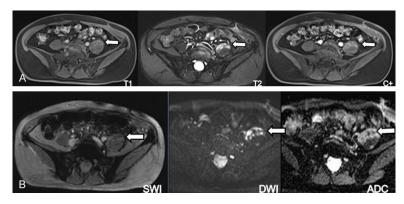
MRI follow-up. A. The mass is iso-and low signal intensity on axial T1-weighted image; hyperintense on T2-weighted image; with heterogeneous enhancement after contrast administration. B. The SWI showes multiple punctate signal voids within the mass, and the contents of it are hyperintense on DWI and bright on ADC. White arrow shows the lesion.
